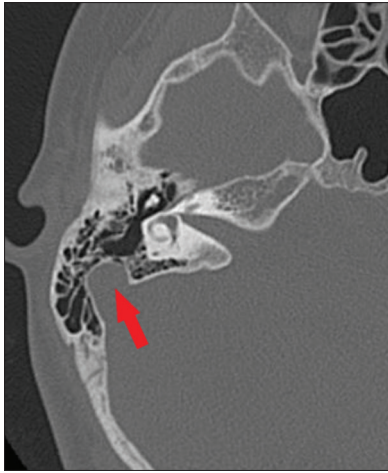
Axial CT image of temporal bone shows the significant anterior location of the sigmoid sinus (red arrow: sigmoid sinus)
